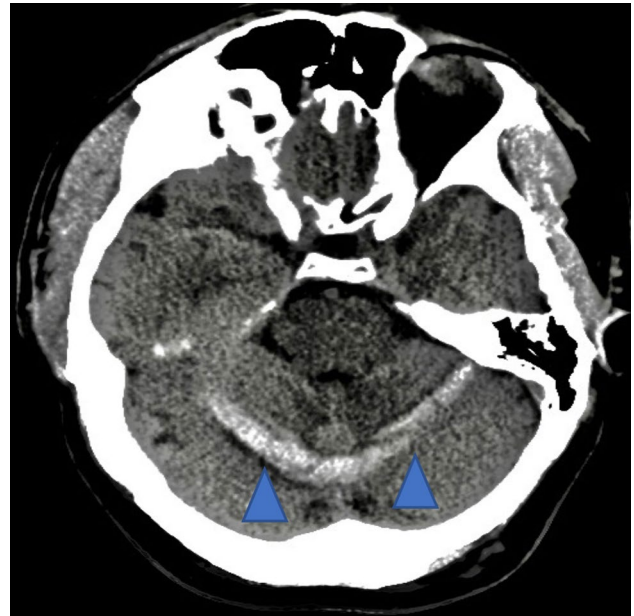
An axial section of the brain computed tomography displaying bilateral cerebellar hyperdensity corresponding to hemorrhage.
